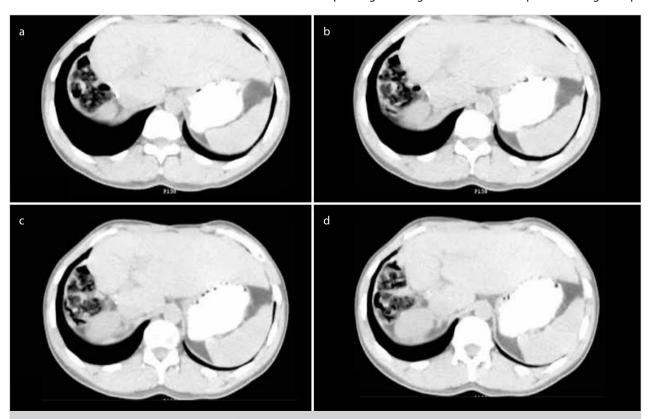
a-d. PET-CT images of second-year follow-up. Consecutive axial sections are presented
